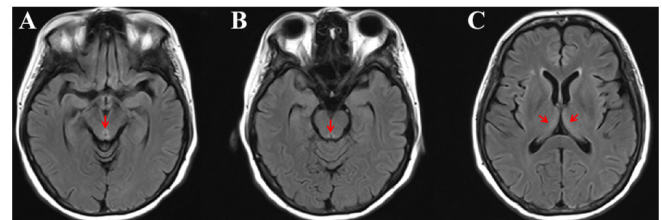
Brain magnetic resonance imaging. (A) T2 FLAIR imaging showing hyperintensity in the periaqueductal midbrain (arrow). (B) T2 FLAIR imaging showing hyperintensity in the periaqueductal gray matter (arrow). (C) T2 FLAIR imaging showing hyperintensity in the thalami (arrow). FLAIR, fluid-attenuated inversion recovery.
